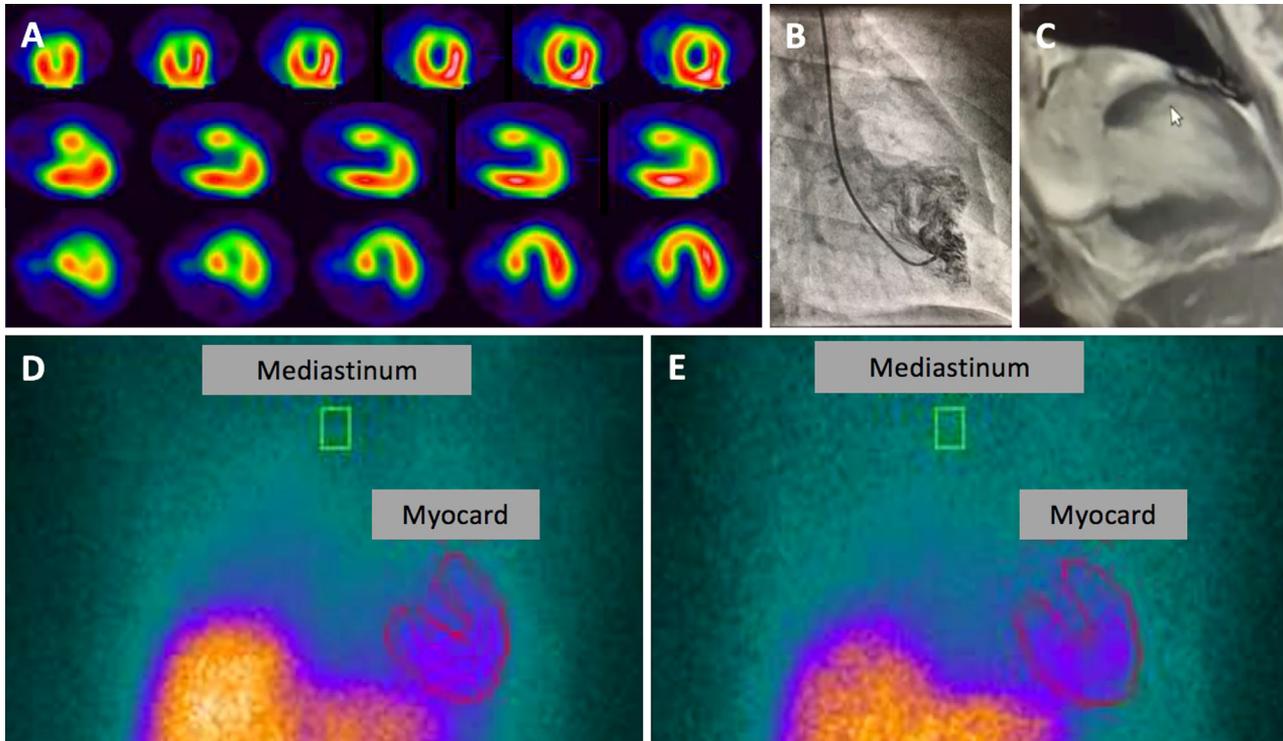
(A) SPECT perfusion images obtained when the tracer was injected during pain. There are anterior and septal perfusion defects. (B) Left ventriculography in the right anterior-oblique projection showing anterior wall motion abnormality, (C) Cardiac MRI shows no delayed gadolinium enhancement, (D) early planar I-123 MIBG images in the anterior projection (the mediastinum and myocardium regions are outlined), (E) late I-123 images.
